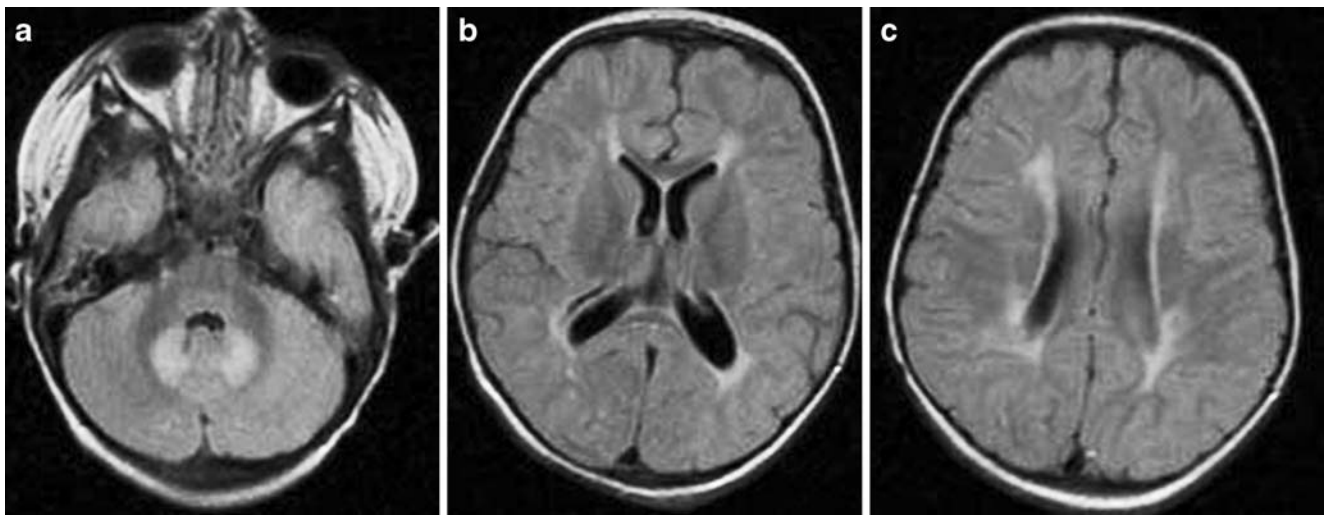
Axial T2 FLAIR through the posterior fossa, basal ganglia and centrum semi-ovale in a 2-year-old girl with PVL, who was born at 27 weeks' gestation. a The dentate nuclei show abnormal high
